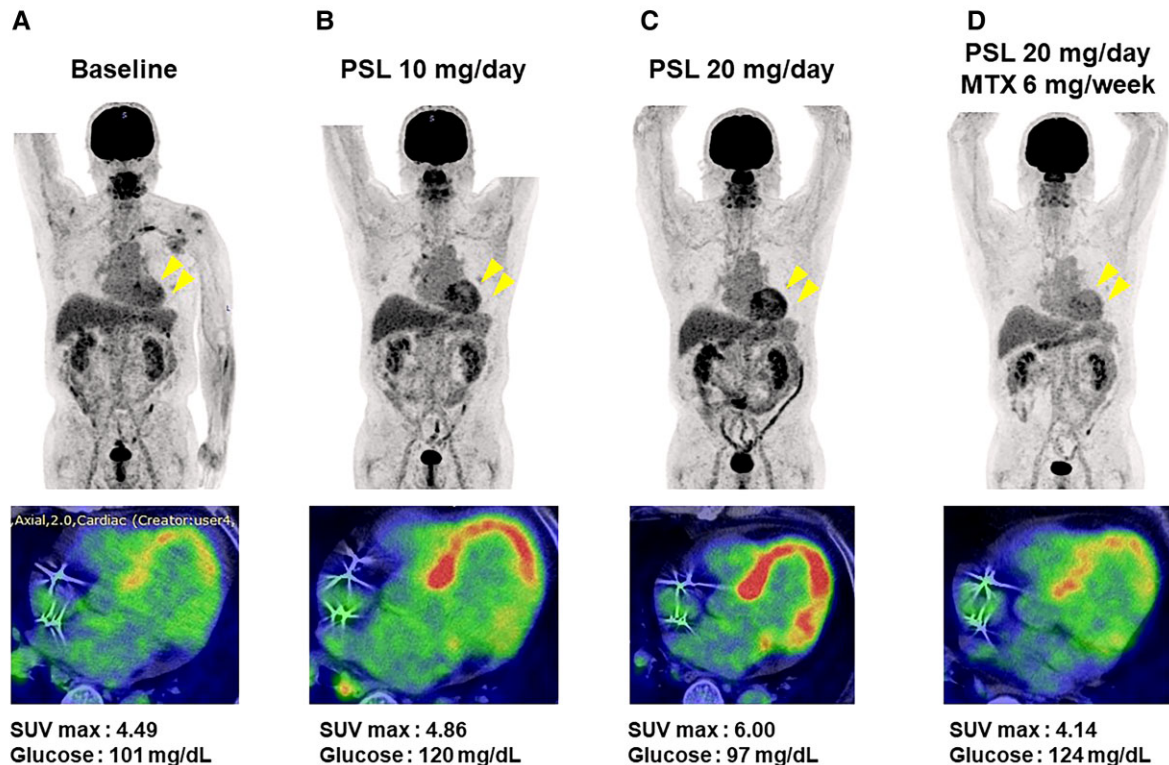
Serial changes in ^{18}F -fluorodeoxyglucose (FDG) uptake. (A) shows the baseline FDG uptake without corticosteroid treatment; (B) shows increased FDG uptake with a corticosteroid dose of 10 mg/day; (C) displays increased FDG uptake despite up-titration of the corticosteroid dose to 20 mg/day; and (D) shows significantly decreased FDG uptake with the addition of methotrexate to a stable corticosteroid dose. FDG, ^{18}F -fluorodeoxyglucose; MTX, methotrexate; PSL, prednisolone; SUV, standardized uptake value.
